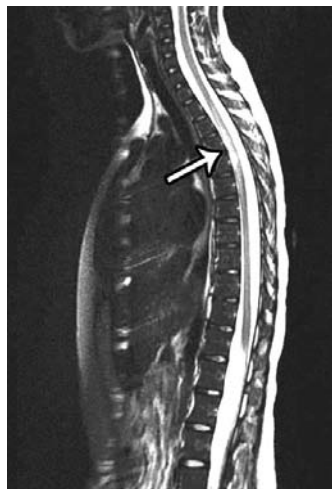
Patient MRI sagittal T2 of dorsal spine showing high signal intensity of the cord at the T4 to T6 level.
